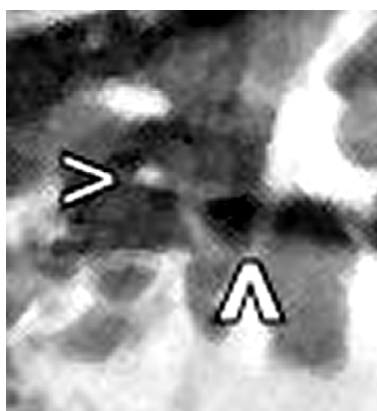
Stapes imaged by CBCT (IV). Thin arrowhead: head, and thick arrowhead: footplate of the stapes; coronal view.
